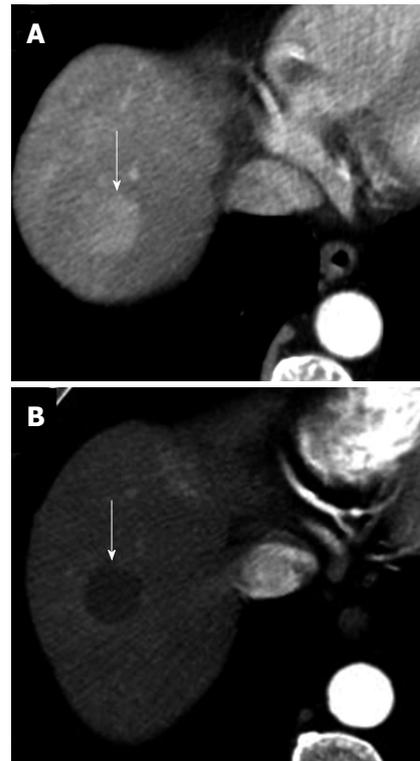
Complete hepatocellular carcinoma necrosis after transarterial chemoembolization with drug-eluting beads. A: Pretreatment arterial phase computed tomography (CT) shows a hypervascular hepatocellular carcinoma (HCC) (arrow); B: Arterial phase CT obtained 3 mo after transarterial chemoembolization shows a hypoattenuating, non enhancing nodule (arrow). Absence of arterial enhancement suggests complete HCC necrosis.
